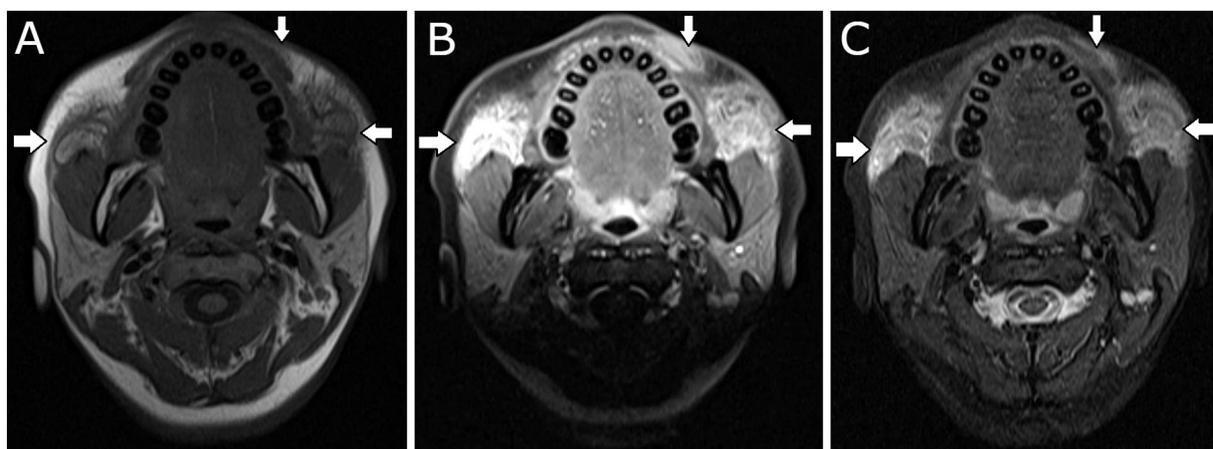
Axial MR images at the level of the lower maxilla. A) Pre-contrast T1 weighted image demonstrates loss of the normal T1 bright signal within the fat anterior to the bilateral masseters and involving the left upper lip. Instead, there is an infiltrating processes without mass effect, as represented by the dark, reticular T1 signal intensity throughout the fat. The SMAS and vascular structures in the lesion can be seen and there is no evidence of displacement or distortion. B) T1 fat-sat post contrast image clearly demonstrates the inflammatory process, with heterogeneous geographical, reticular enhancement, without mass effect throughout the subcutaneous adipose layer anterior to the bilateral masters and left upper lip. C) Axial STIR at the same level demonstrates abnormal hazy fluid signal intensity, consistent with edema/inflammation.
